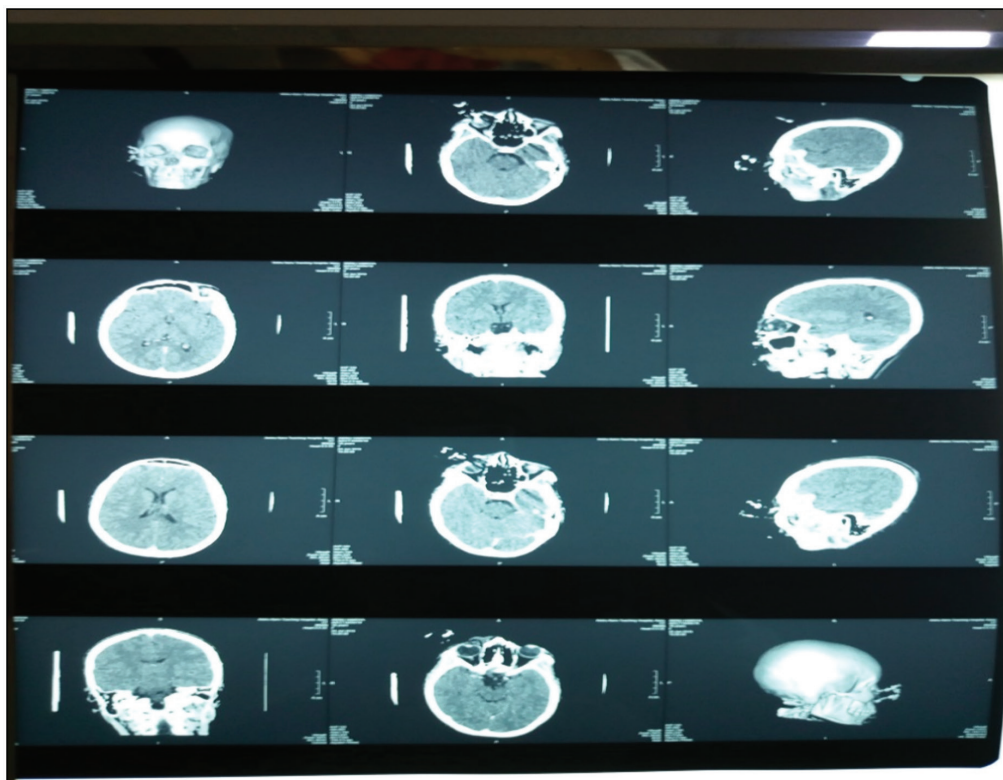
Patient's CT scan of brain and orbit
